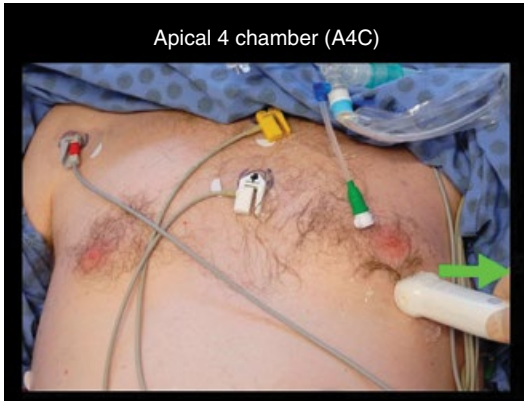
Typical transducer location and orientation for the apical four-chamber (A4C) window. Using the cardiology screen orientation, the marker is directed towards the patient's left ('3 o'clock'). In dehydrated patients the apex tends to be more towards the midline, whereas for patients with cardiomegaly it tends to be more lateral.
